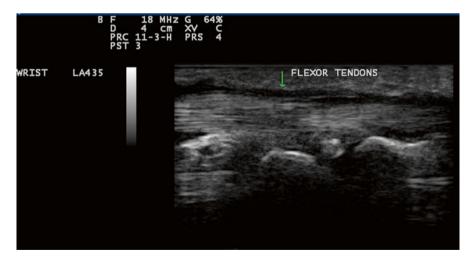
Grayscale ultrasound using Esaote Mylab 25 system. Palmar longitudinal view at the proximal inlet of the carpal tunnel showing tenosynovitis flexors of the hand (US)
